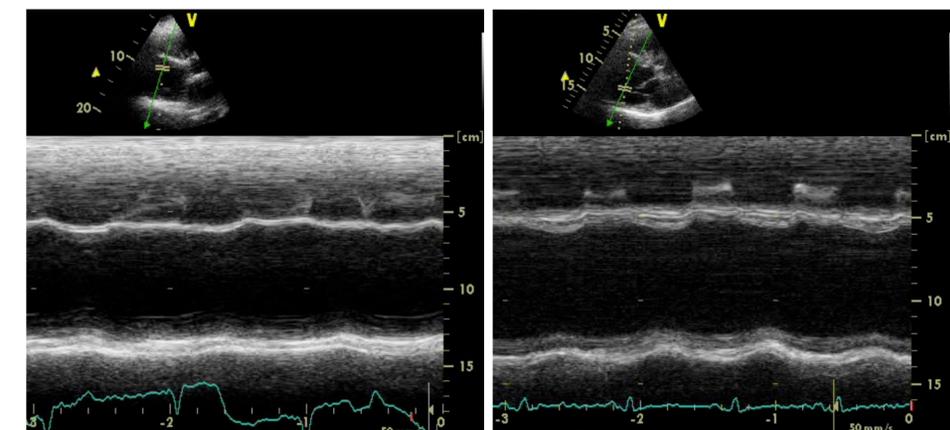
Transthoracic echocardiogram (TTE) of the left ventricle in m-mode at baseline (a) and at follow-up after 7 weeks (b) of patient 3.
